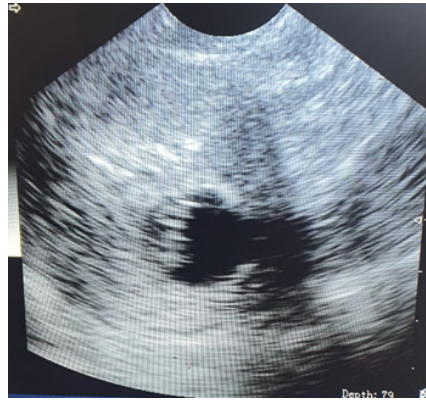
Transabdominal Ultrasonography one week after a Laparoscopic Intrauterine Device removal showing the fetus and the gestational sac within normal limits
